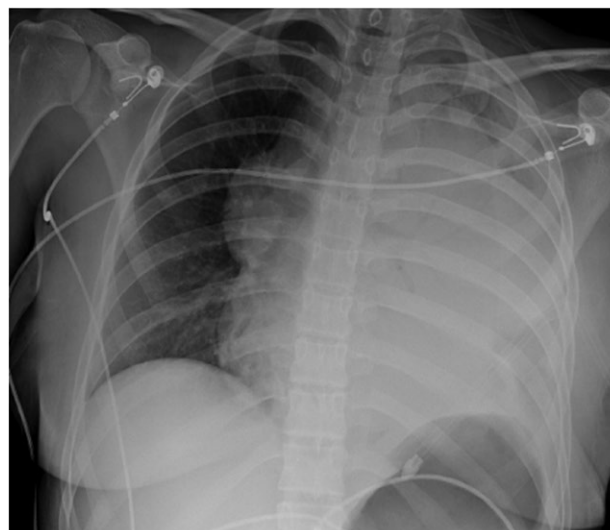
Chest x-ray after drainage.
